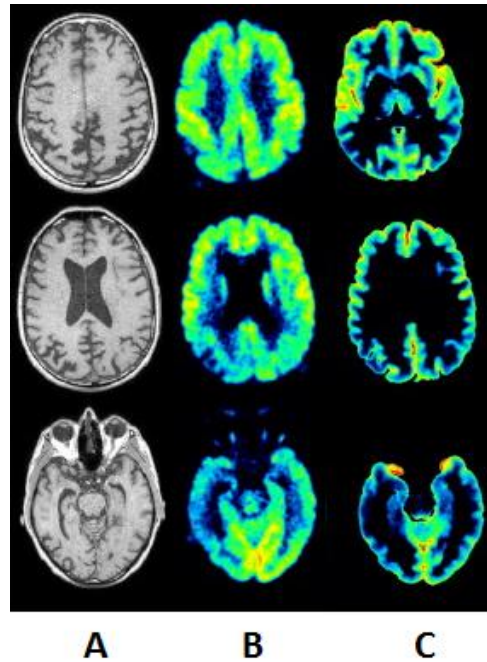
Partial Volume Correction by MG method with grey matter segmentation. A) Original MRI scan used for segmentation; B) Original PET brain image; C) MG PVC corrected image (grey matter).
